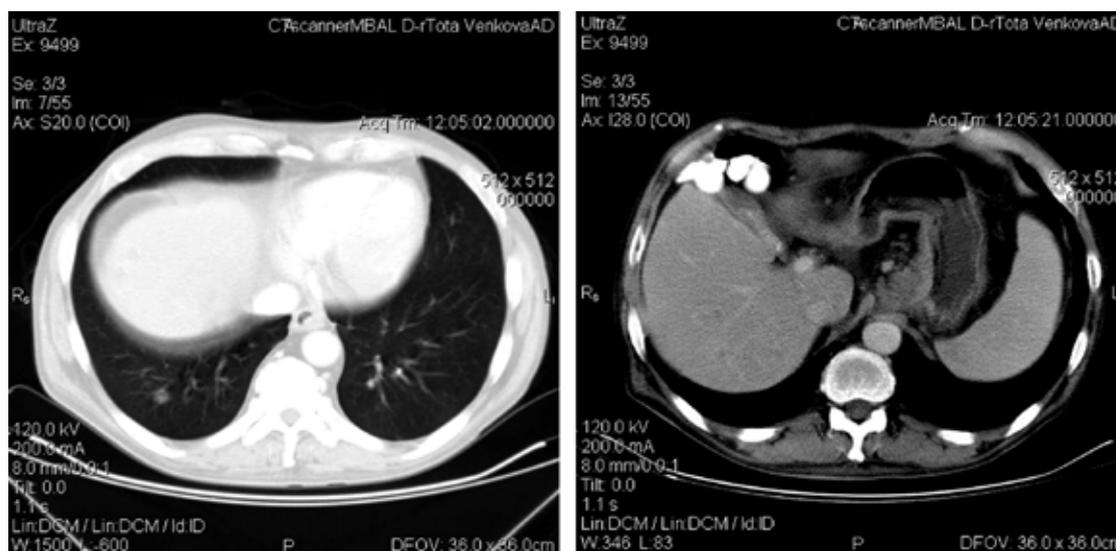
Abdominal CT scan visualizing a mass in the distal part of esophagus, narrowed lumen of the gastric cardia, enlarged gastric lymph nodes, and lung and liver metastases.
